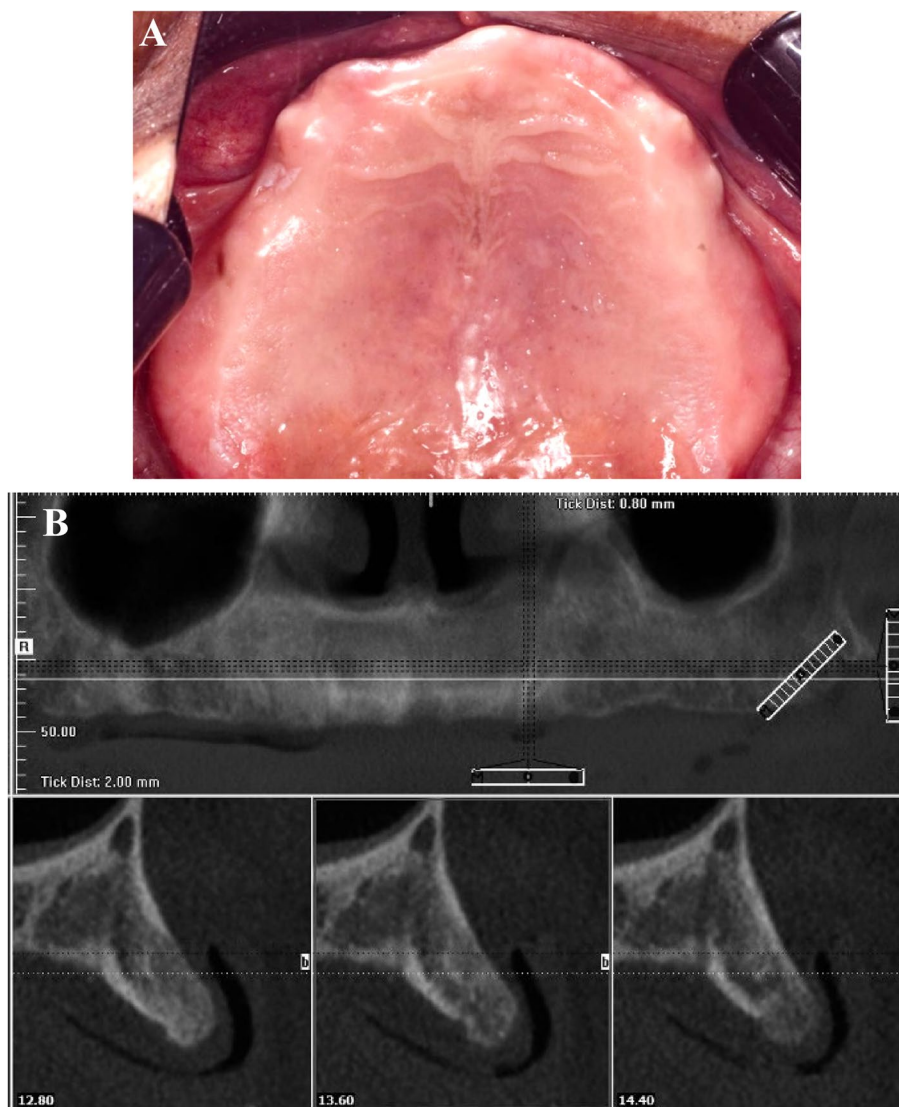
A Completely edentulous maxilla, B Preoperative CBCT
